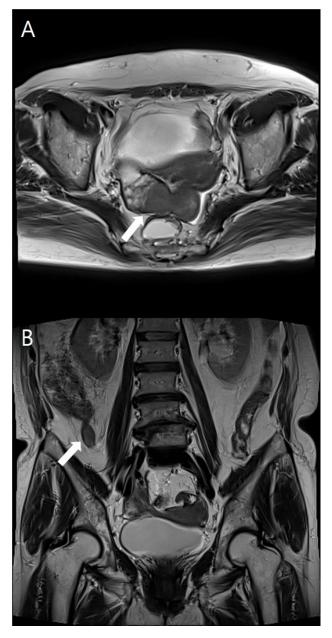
(A) Axial contrast-enhanced T2-weighted pelvic MRI shows a 6.0×3.5 cm sized lobulated right fallopian tubal mass with heterogenous enhancement (arrow). (B) Coronal contrast-enhanced T2-weighted pelvic MRI shows a 1.9×1.4 cm sized mass in the tip of appendix with heterogenous enhancement (arrow).
